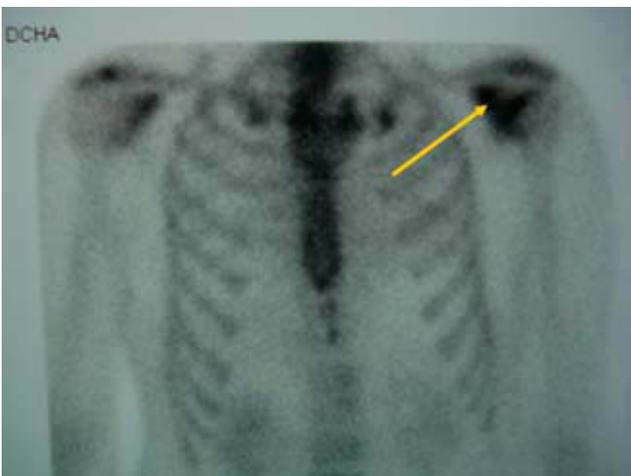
X-Ray. Area of increased intensity in the humeral head suggestive of osteonecrosis.
